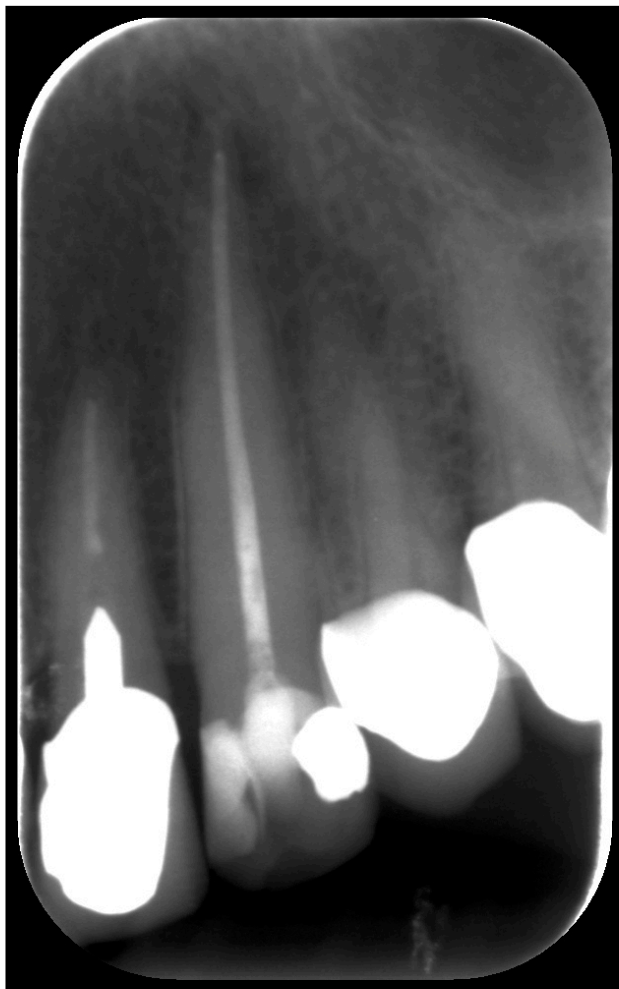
Pretreatment radiograph
